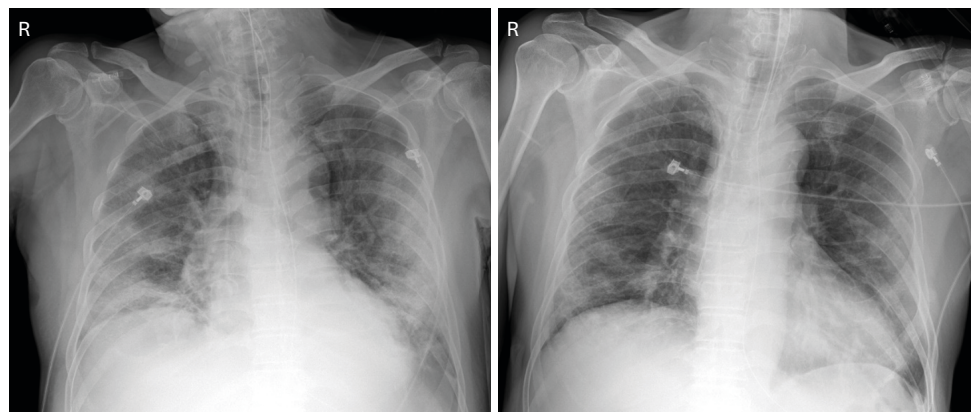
Chest X-rays of Case 1 taken before and after convalescent plasma infusion. Taken on day 7, just before the convalescent plasma infusion (left). Taken on day 13 shows marked improvement of bilateral infiltrations (right). The images are published under agreement of the patient.
